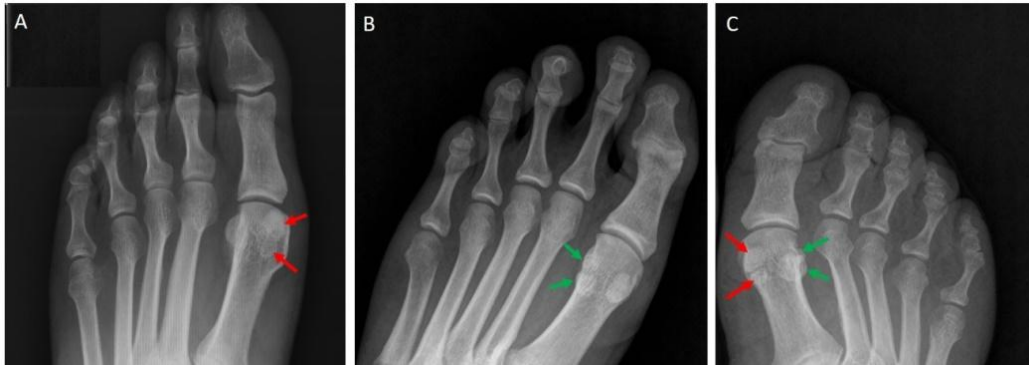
AP radiographs showing A: bipartite medial hallucal sesamoid (red arrows) in a 29-year-old female, B: bipartite lateral hallucal sesamoid (red arrows) in a 49-year-old male, and C: bipartite medial and lateral hallucal sesamoids (red and green arrows) in a 61-year-old female
